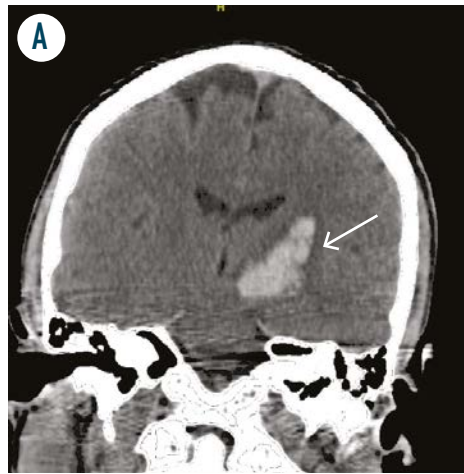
Coronal CT head shows an acute intraparenchymal bleed in the left basal ganglia →. (Figure author provided)
